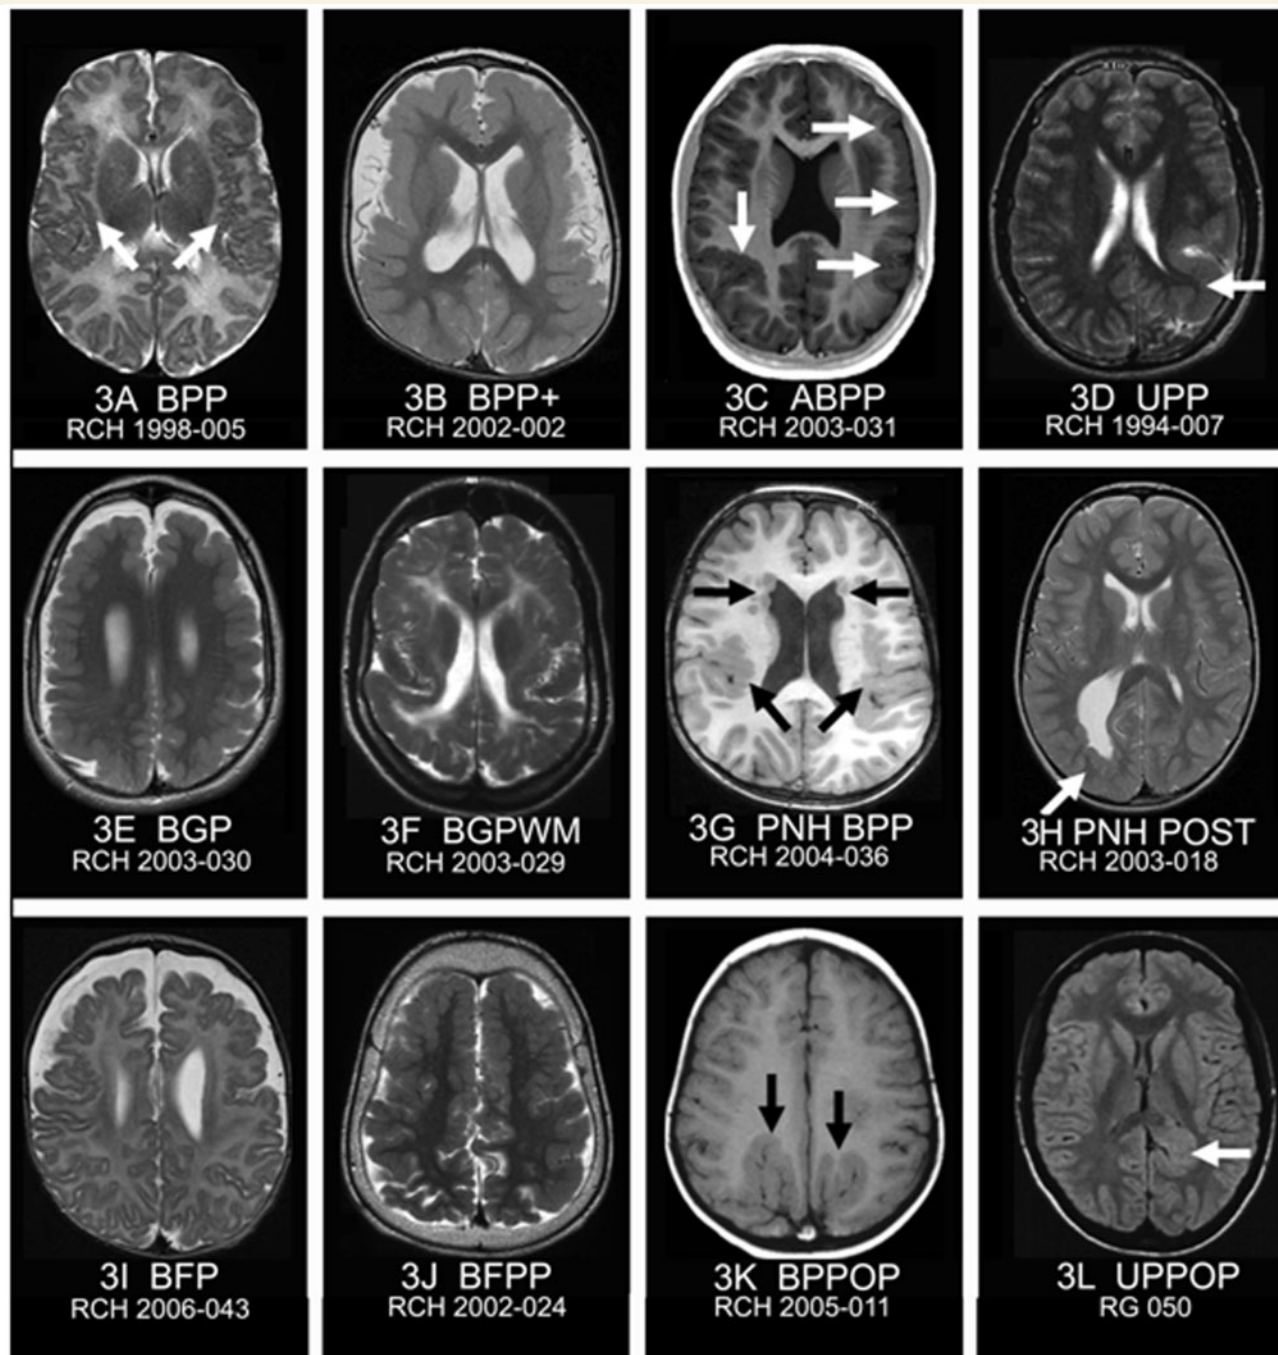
MRI features of common patterns and subtypes of polymicrogyria. All images are T₁, T₂ or fluid attenuated inversion recovery axial. (A, B) Bilateral perisylvian polymicrogyria with polymicrogyria either limited to the perisylvian cortex (BPP), or extending beyond it (BPP+). (C) Asymmetric bilateral perisylvian polymicrogyria (ABPP) with polymicrogyria involving the posterior third of the right Sylvian fissure and the left Sylvian fissure along its entire length (arrows). (D) Unilateral perisylvian polymicrogyria (UPP) with polymicrogyria lining the left Sylvian fissure that is abnormally extended postero-superiorly. (E) Bilateral generalized polymicrogyria (BGP) showing no clear gradient or region of maximal severity. (F) Bilateral generalized polymicrogyria with abnormal white matter (BGPWM). Note abnormal high signal in the subcortical and deep white matter. (G) Bilateral periventricular grey matter heterotopia with bilateral perisylvian polymicrogyria (PNH BPP) (arrows). (H) Right-sided posterior periventricular grey matter heterotopia (arrow) associated with overlying polymicrogyria (PNH POST). (I) Bilateral frontal (only) polymicrogyria (BFP) with bilateral symmetric polymicrogyria involving the majority of the frontal lobes with abrupt cut-off in the mid-frontal regions. (J) Bilateral frontoparietal polymicrogyria (BFPP) with bilateral symmetric polymicrogyria involving the frontal lobes and extension posteriorly into the parietal lobes. (K) Bilateral parasagittal parieto-occipital polymicrogyria (BPPPOP) with bilateral symmetric polymicrogyria lining abnormal gyri radiating antero-laterally from the parasagittal parieto-occipital region (arrows). (L) A mild form of unilateral parasagittal parieto-occipital polymicrogyria (UPPOP) with polymicrogyria lining a deep and abnormally-oriented sulcus in the left parasagittal region.
